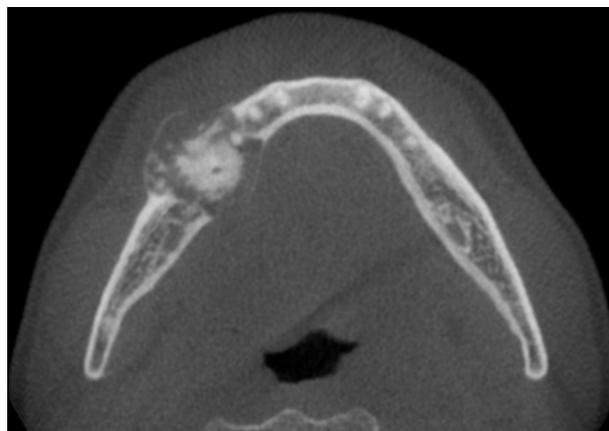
Mandibular lesion on preoperative computed tomography.
